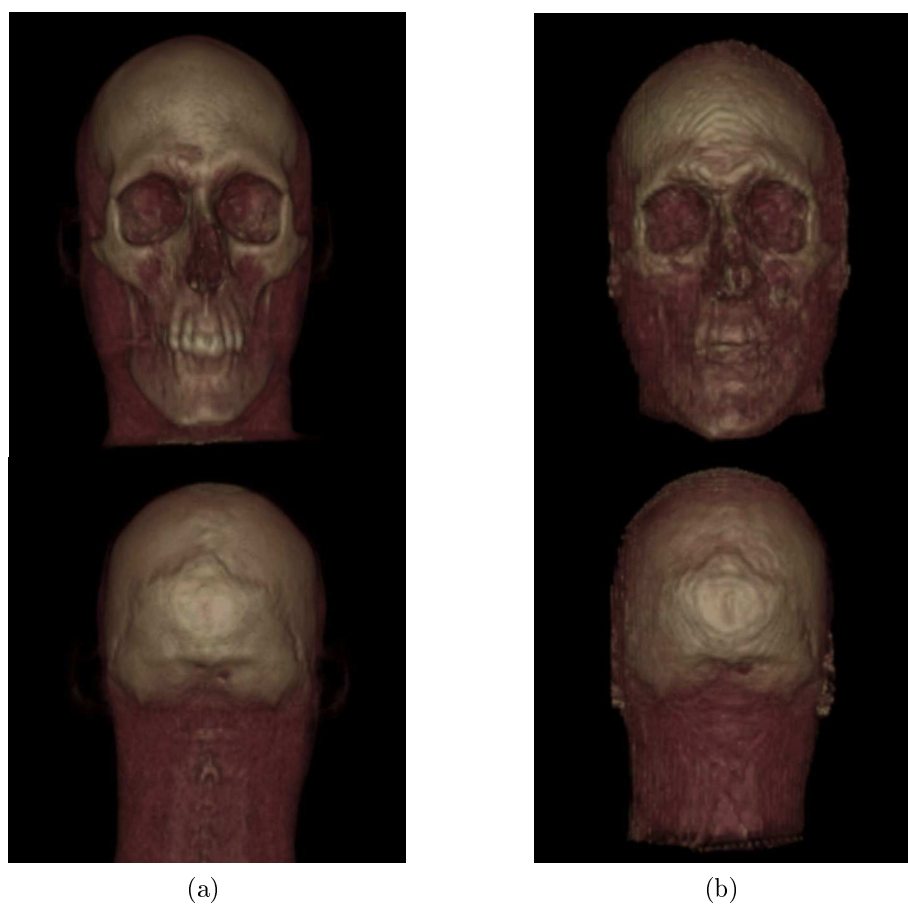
(a) Skull renderings of the CT and (b) the corresponding pseudoCT for the same patient for both the front and back side of the head. The pseudoCTs bear a good similarity to the CT for most part of the head, except for dental regions where there was an absence of sufficient signal in UTE-TE1.
